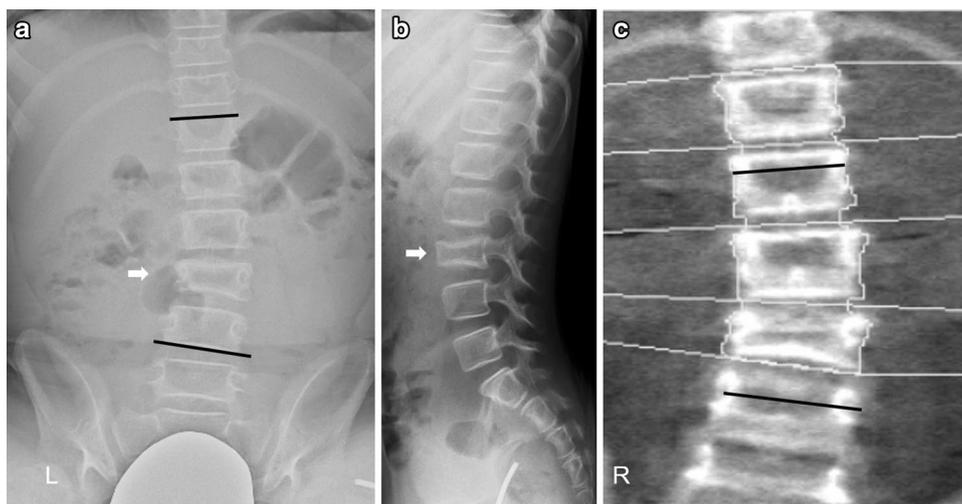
Images of an 8-year-old girl with Sillence type III osteogenesis imperfecta, Gross Motor Function Classification System level 5. Pamidronate (PAM) was first administered when the child was 3 years of age, and the total number of PAM doses was 14. a A frontal whole-spine radiograph with the patient sitting: T12–L4 Cobb
